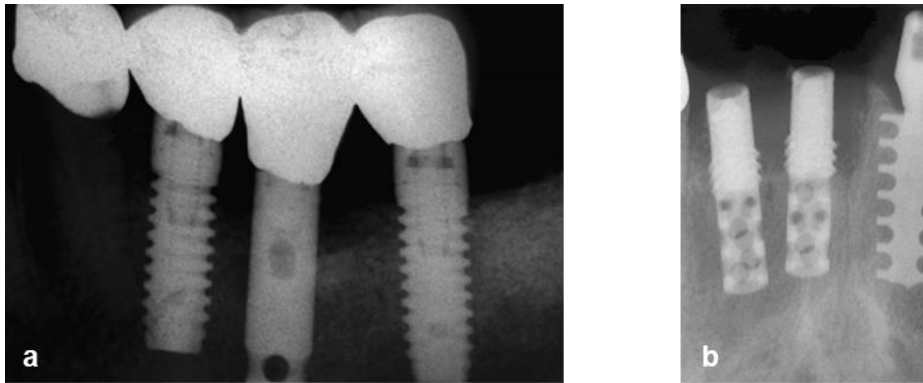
Dental implants X-ray images. (a) A hollow cylinder implant (*center*) was splinted to two solid screw implants (*left* and *right*). (b) Two hollow cylinder implants (*left* and *center*) were splinted to a solid plateau implant (*right*). In both cases, after several years, more crestal bone loss was observed on the hollow implants. Adapted from [43].
